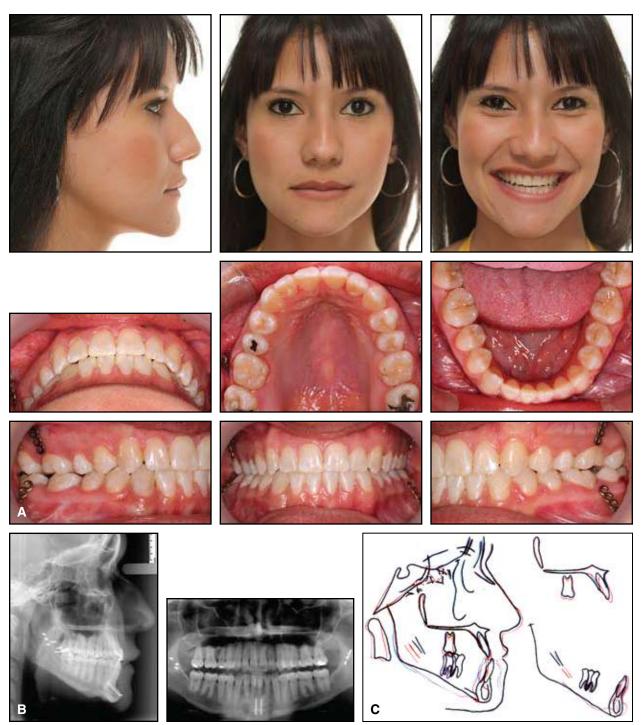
A. Patient after seven months of treatment. B. Radiographs taken six months later, after removal of miniplates at end of retention period. C. Superimposition of cephalometric tracings before treatment (black), immediately after surgery (blue), and after six months of retention (red).
